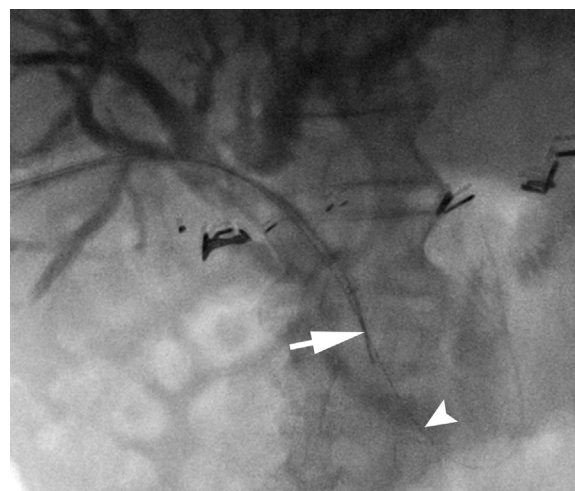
Fluoroscopic image during transbiliary biopsy demonstrating location of the core biopsy needle (white arrow) which was directed by IVUS reference. Note a safety wire within the proximal bowel (white arrowhead). IVUS, intravascular ultrasound.
